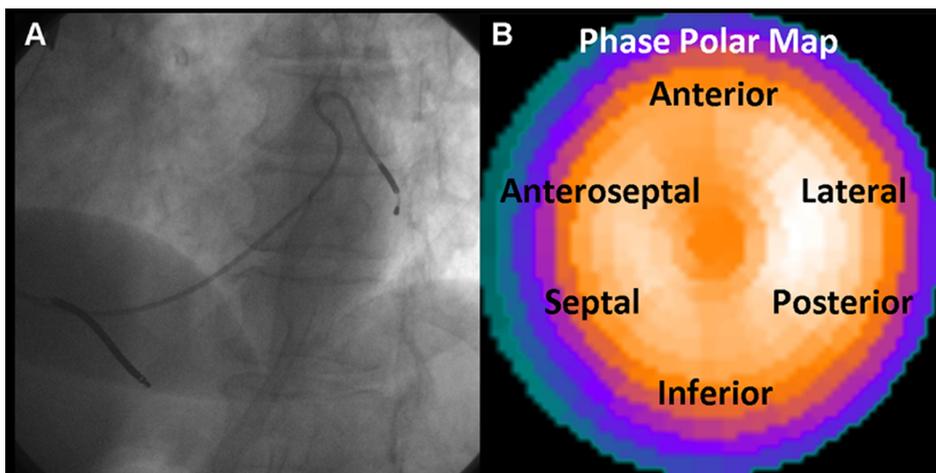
The site of latest mechanical activation was assessed on gated myocardial perfusion single photon emission computed tomography (SPECT) (GMPS) (panel B) and related to the left ventricular (LV) lead position on fluoroscopy (panel A).
